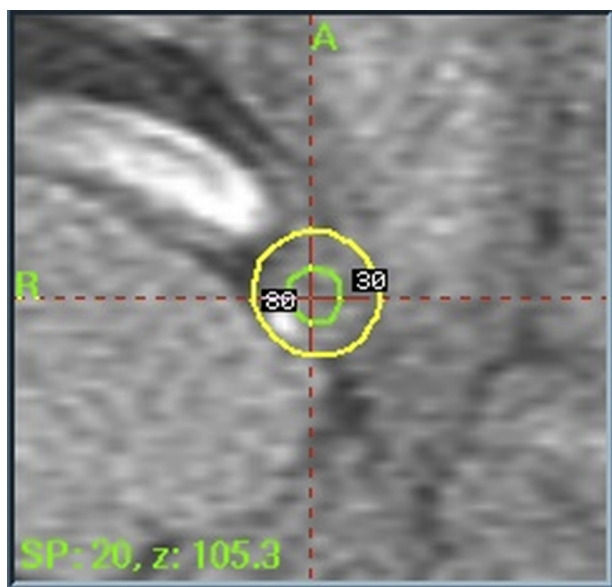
Axial magnetic resonance imaging (MRI) shows the radiation dose plan (Leksell GammaPlan Wizard 5.34). The 30% and 80% isodose lines are shown. Note that the vertebral artery and the bifurcation of the anterior inferior cerebellar artery (AICA) are outside the 30% isodose line.
